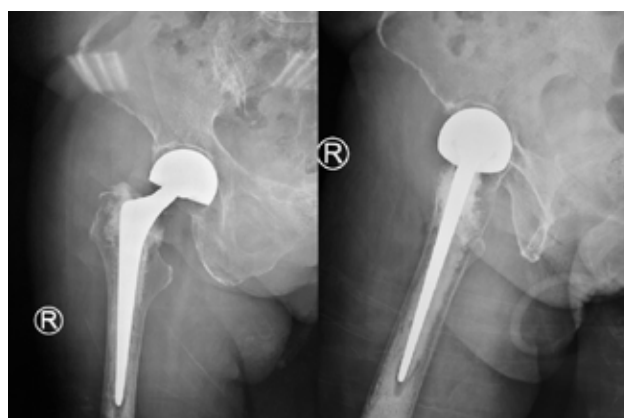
Right hip X-ray showing bipolar hemiarthroplasty
